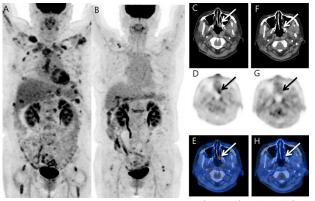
Maximum intensity projection (MIP, A) and axial (C-E) images from baseline [¹⁸F] FDG PET/CT show multiple FDG-avid osteolytic lesions. MIP (B) and axial (F-H) images from posttreatment 2-[¹⁸F] FDG PET PET/CT show resolution of the abnormal FDG uptake previously seen with the left nasal cavity lesion and decreased than before FDG uptake associated with the multiple osteolytic lesions. The patient is currently under maintenance chemotherapy.
